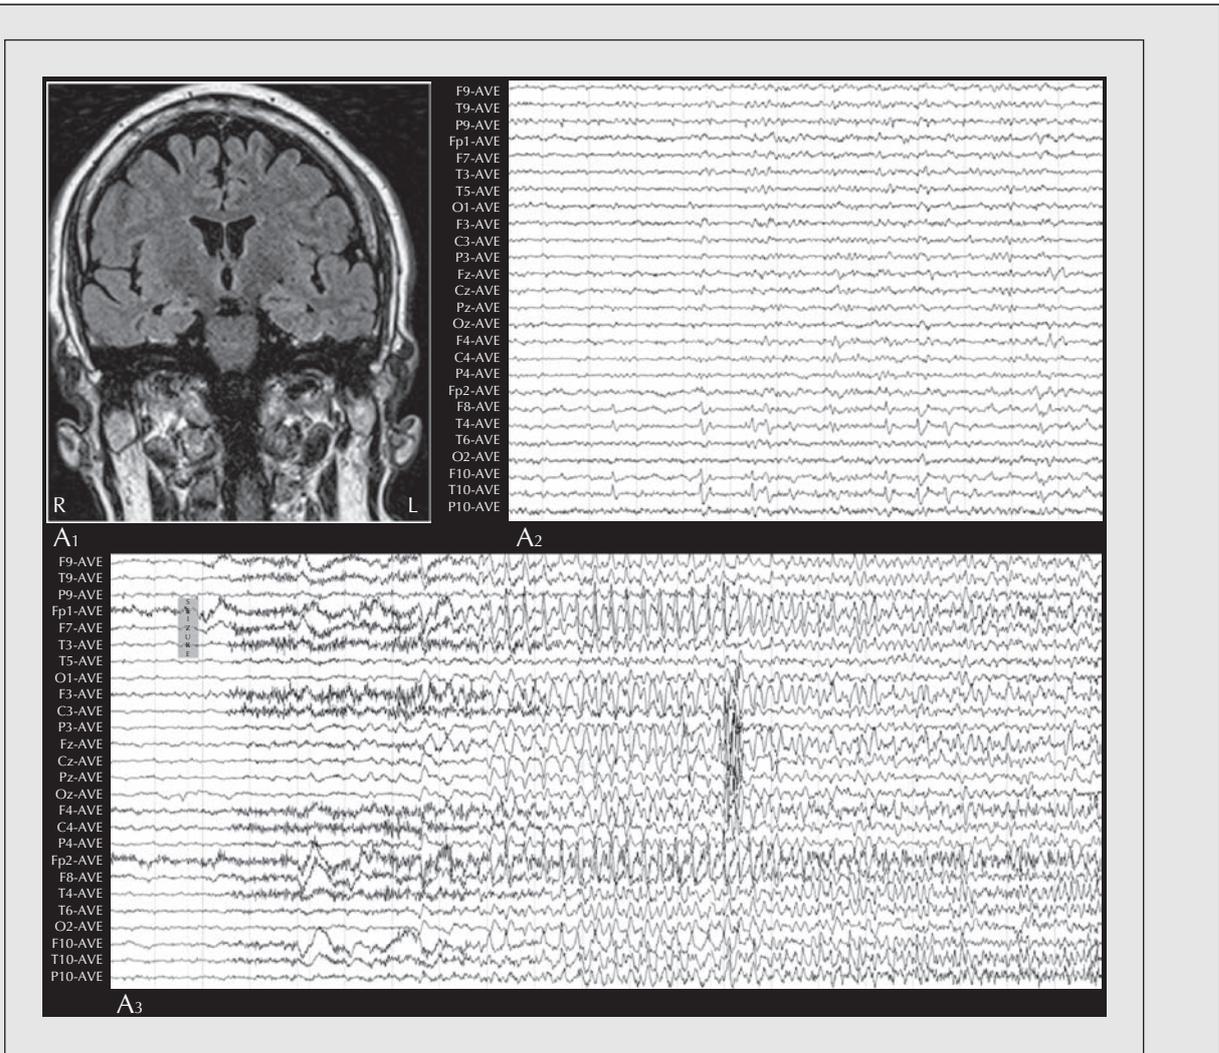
Patient 2. (A₁) MRI showing high intensity signal over the right medial temporal area. (A₂) Interictal EEG of a typical right anterior SW focus (F8/T4/F10/T10). (A₃) Ictal EEG presenting bilateral frontopolar-frontal repetitive SW activity (Fp2/F4/Fp1/F3), followed by a right temporal sustained and well-organised “theta/alpha” rhythm.
